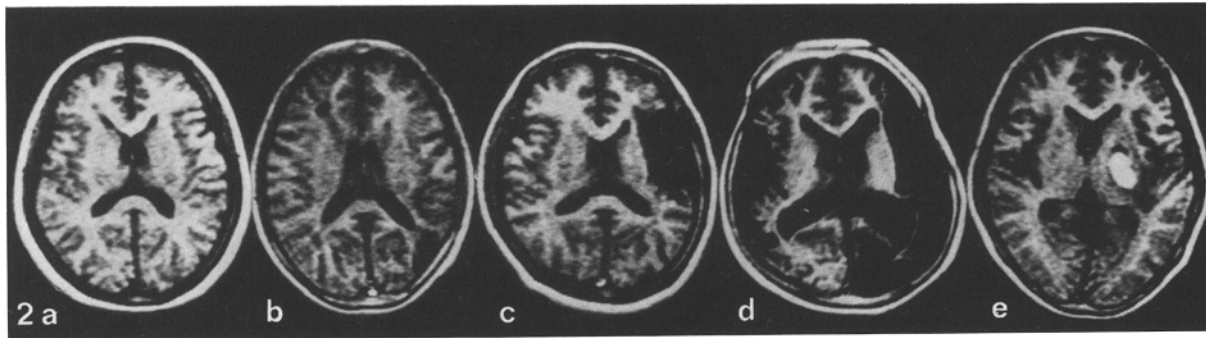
a–e. Classification of CT in moyamoya disease (ischemic type). a Type I, normal; b type II, small watershed infarct with localized cortical atrophy; c type III, large watershed infarct in frontal or occipital area with localized cortical atrophy; d type IV, large cerebral infarcts in both cerebral hemispheres with diffuse cortical atrophy and large ventricles. Hemorrhagic type: e type V, intracerebral hemorrhage
